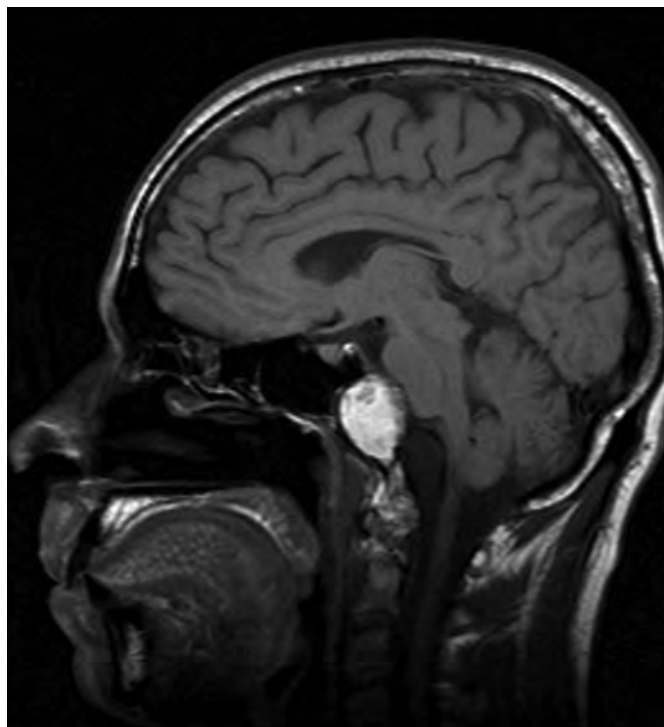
Sagittal T1-weighted magnetic resonance imaging demonstrating the spontaneously hyperintense clival-based lesion.
